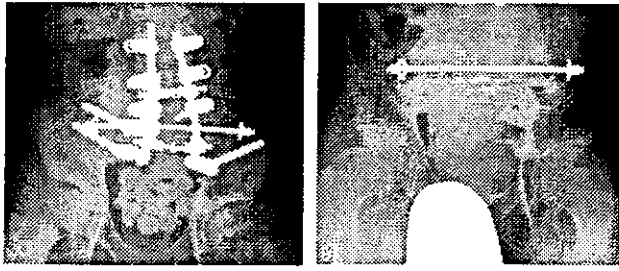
A: Postoperative radiograph shows the massive skeletal reconstruction and the bag of antibiotic impregnated cement beads. B: Radiograph shows Zielke rod, which was left after removal of the ISOLA system due to infection.
